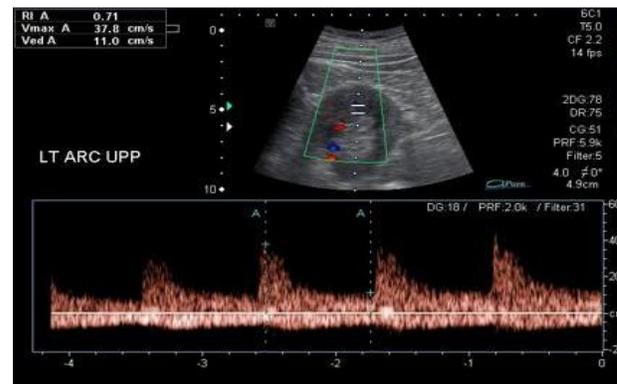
Left upper pole arcuate artery doppler showing RI 0.7.
